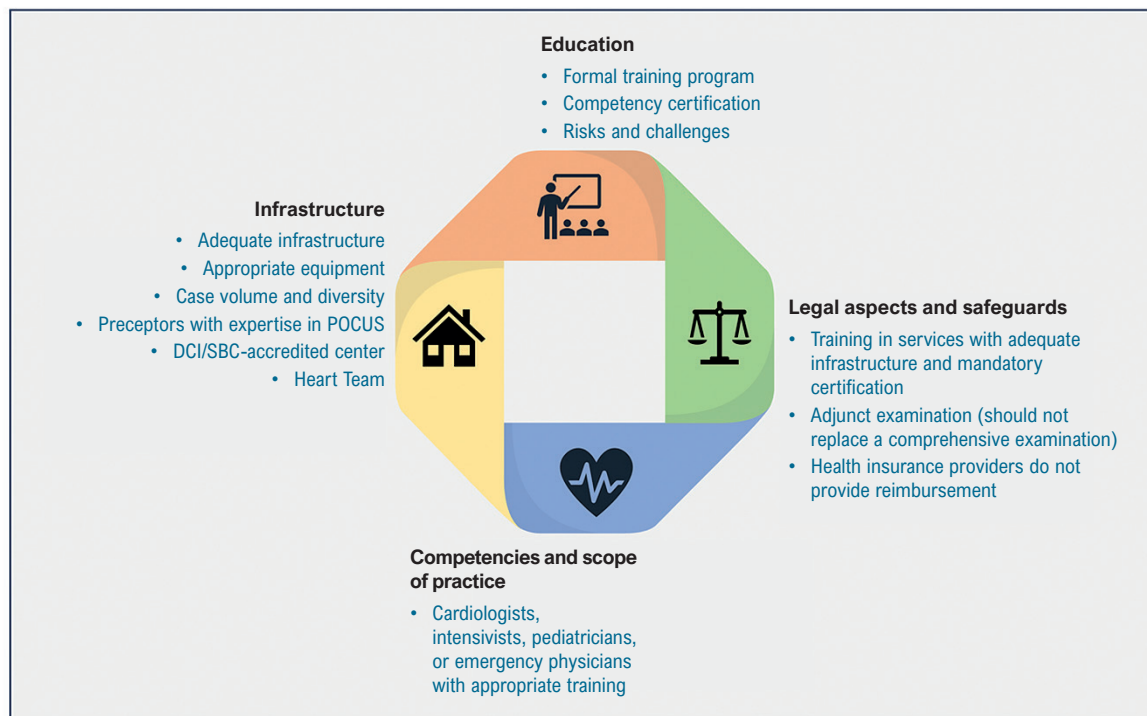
Prerequisites for POCUS implementation in a health care service. *Cardiac abnormalities identified in this age group should raise suspicion of congenital heart disease, and a comprehensive examination by a pediatric echocardiographer should be performed as soon as possible. DCI: Department of Cardiovascular Imaging; POCUS: point-of-care ultrasound; SBC: Brazilian Society of Cardiology.
